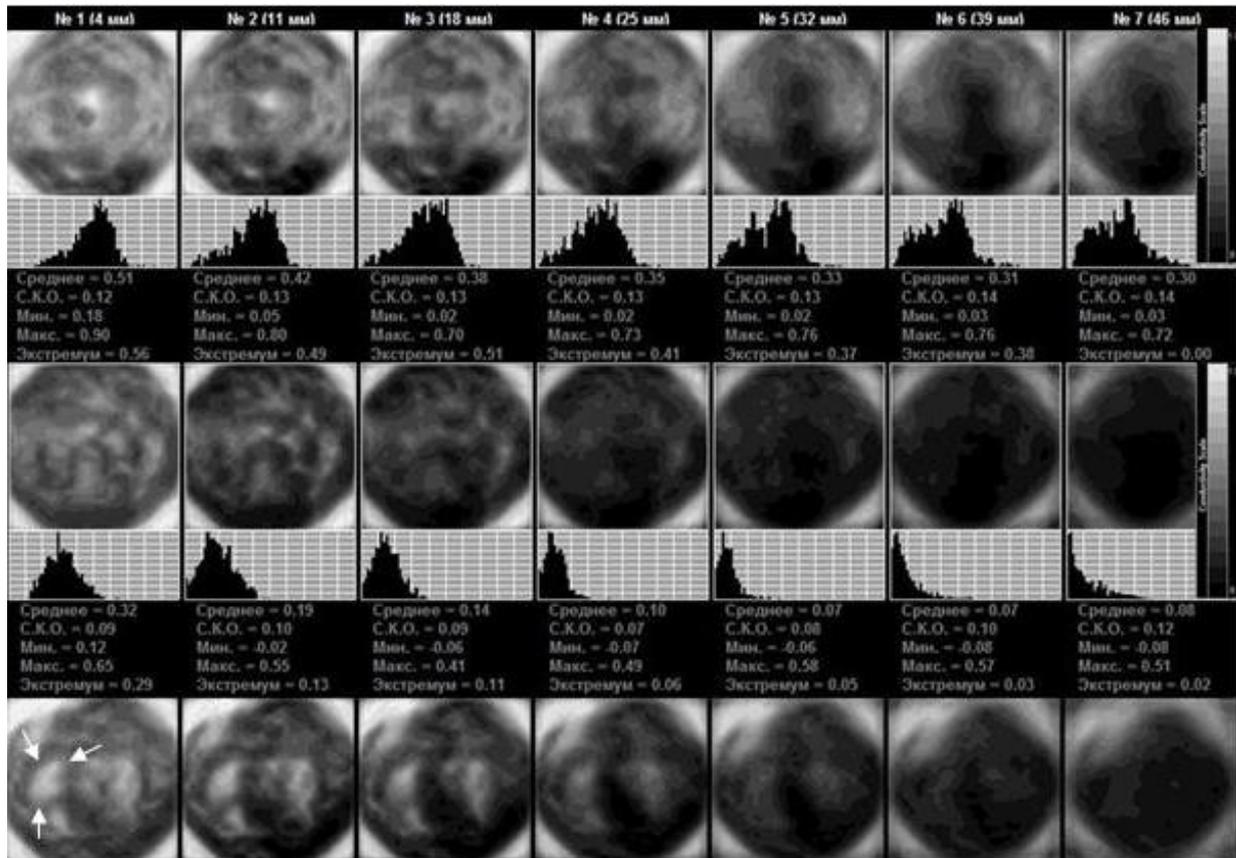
EIM. Top row – left gland. Mixed type of mammary gland structure. Middle row – right gland. Well-defined hyper-impedance background. The anatomy is altered. Electrical conductivity index is significantly reduced. The lower row represents the upper segment. At 9 o'clock position there is an iso-impedance formation measuring 17x24 mm. ULTRASOUND: In the boundary of the outer segments of the right gland there is observed an inhomogeneous avascular formation without distinct contours, 18x12 mm in size.
